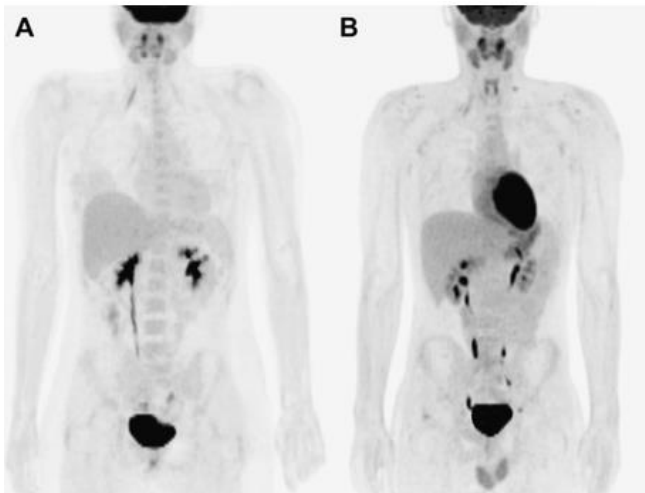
Normal uptake and accumulation of ^{18}F -FDG in the genitourinary tract. Physiologic ^{18}F -FDG uptake frequently is identified in the reproductive organs. (A) In a 15-year-old girl around the ovulation phase of her menstrual cycle (13).
